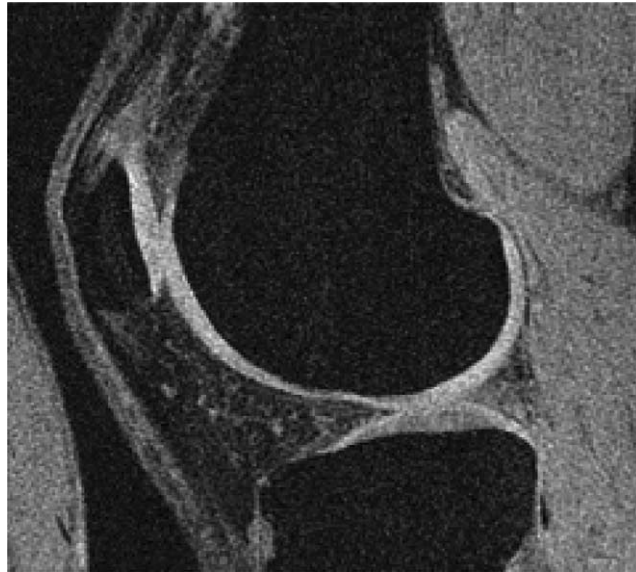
Sample sagittal MR image (fat-suppressed 3D SPGR) of knee used to estimate articular cartilage thickness.
